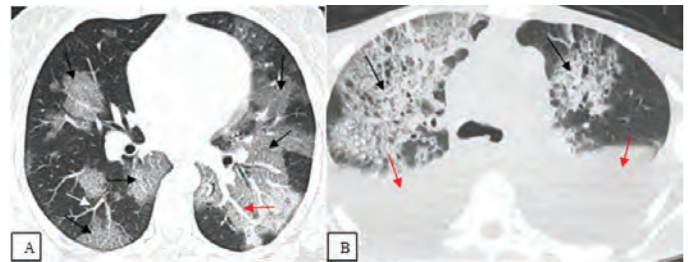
Axial CT images showing. A) multifocal peripheral and central/peribronchovascular GGOs superimposed with reticularion resulting in crazy paving pattern (A, black arrows) in a 33-year-old immunocompetent patient presenting with cough, dyspnea, and chest pain, who had a history of the atrial septal defect and who was discharged 15 days after being hospitalized for COVID-19 pneumonia in a 55-year-old immunocompromised patient presenting with fever, cough, dyspnea, and weakness. Note also the perilesional (A, white arrow) and intralesional (A, red arrow) microvascular dilations B) Bilateral consolidative opacities at the circumferences of structural damaged emphysematous pulmonary parenchyma, which is more prominent in the right lung (B, black arrows). Note the presence of bilateral pleural effusion (B red arrows) in this immunocompromised patient presenting with fever, dyspnea, and cough who had a history of essential thrombocytosis and died 15 days after being hospitalized for COVID-19
